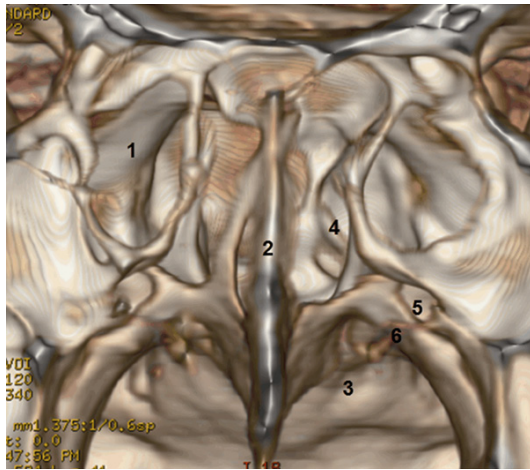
CT three-dimensional reconstruction of anterior area of sphenoid sinus. CT images were collected from 12 patients. The front view of anterior area of sphenoid sinus was shown. The sphenoid ostium and sphenopalatine foramen were close to each other. Posterior nasal septum artery passed through lower edge of sphenopalatine foramen, then divided into two branches and extended to nasal septum along the anterior sphenoid sinus wall. Numbers in this figure indicated the following structures: 1. Posterior ethmoid cell; 2. Nasal septum; 3. The posterior choanae; 4. Sphenoid ostium; 5. Sphenopalatine foramen; 6. Posterior septum artery.
